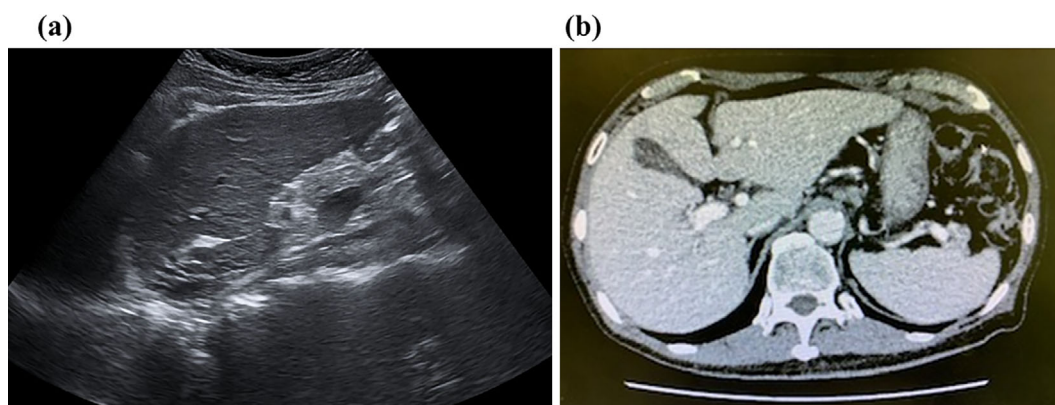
Findings of abdominal ultrasound (US) (a) and computed tomography (CT) (b). (a) US showed a cirrhotic liver with coarse parenchymal pattern, irregular surface, and dull edge but no space-occupying lesions. (b) Contrast-enhanced CT in the portal-dominant phase showed an irregular surface of the liver and splenomegaly with mild dilatation of the paraumbilical vein but no ascites.
